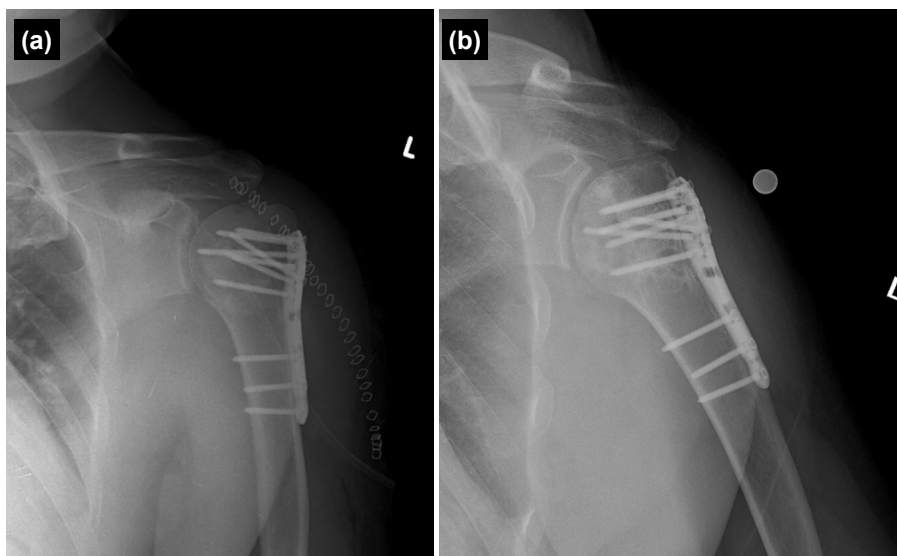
Postoperative true AP view radiographs of the patient no. 3 (a) immediately after surgery (b) at the latest follow-up, 6 years after the surgery.
